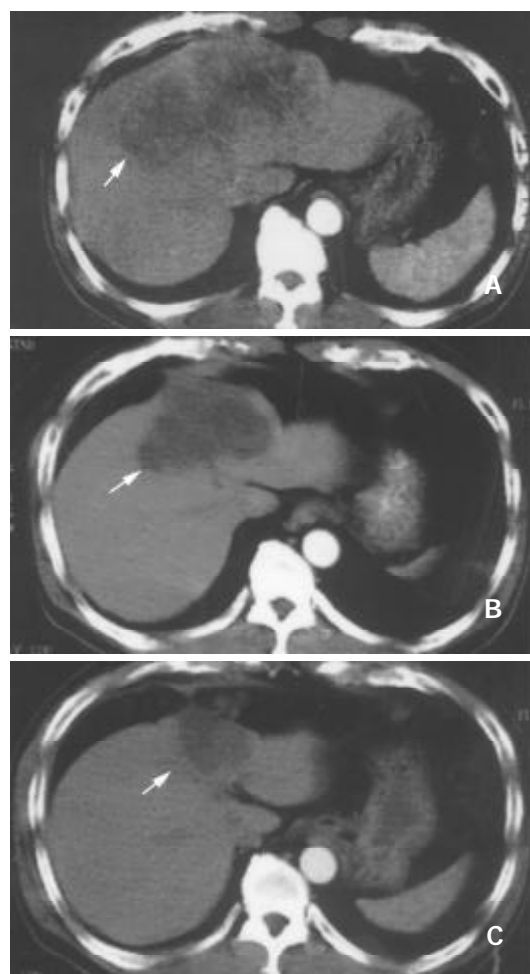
Image study using abdominal computed tomography (hepatic artery phase) of an HCC patient with good partial response to hepatic arterial infusion chemotherapy (HAIC) shows a marked decrease in tumor size from $14\times 10\times 9$ cm (A: before HAIC) to $9\times 8\times 7$ cm (B: 1.5 months after initiation of HAIC) and $5\times 5\times 3$ cm (C: 4 months after initiation of HAIC).
